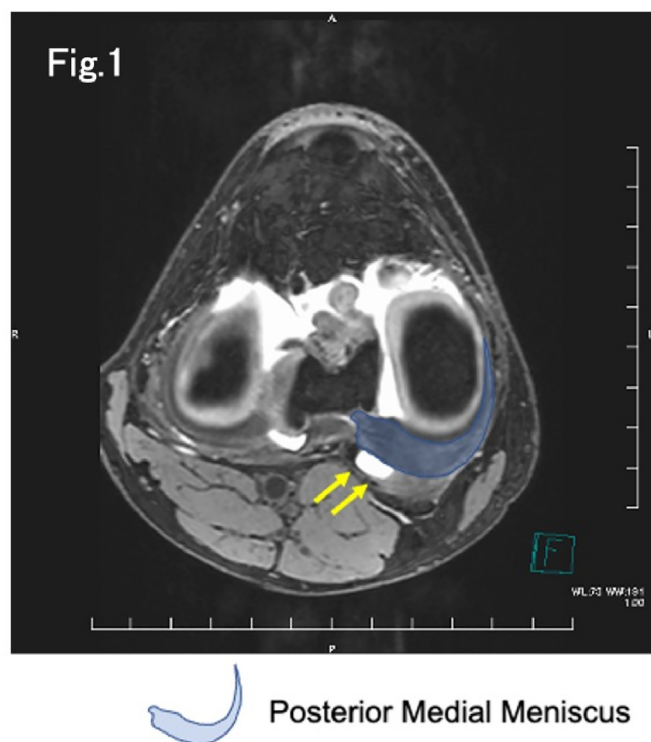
A magnetic resonance image of a ramp lesion (RL) in the axial plane. An RL (arrow) defined as fluid signal intensity just behind the posterior horn of medial meniscus.
